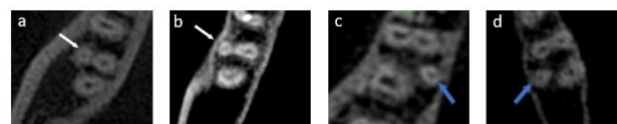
Axial CBCT images of three-rooted mandibular molars; (a-b) RP in the left mandibular second molar (white arrows), (c-d) RE in mandibular first molars (blue arrows).
